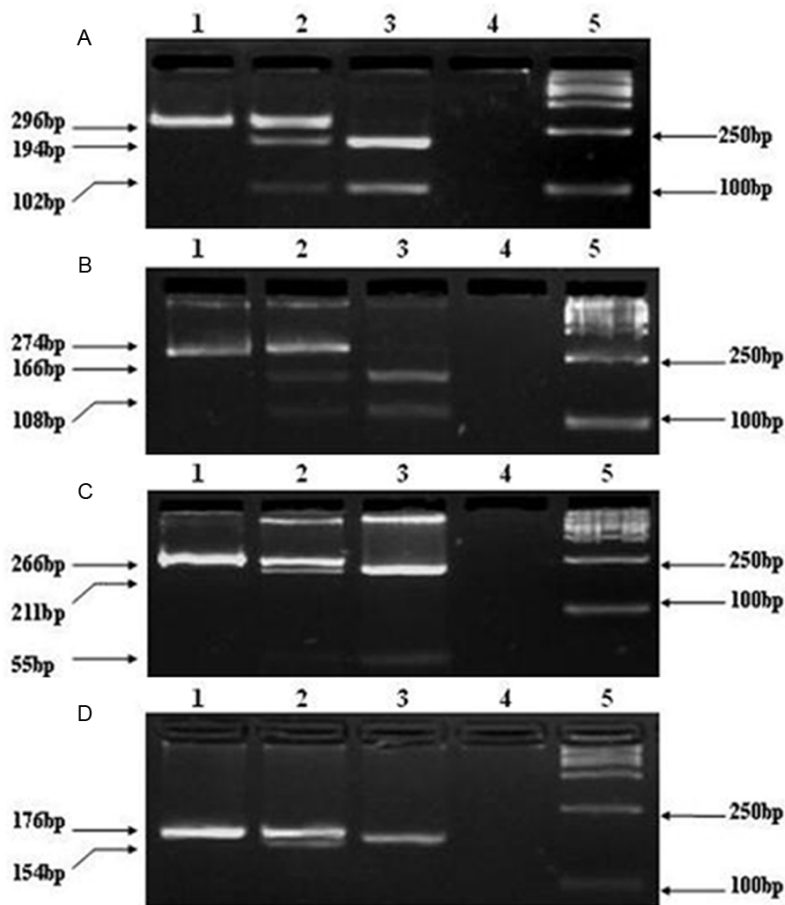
VEGF genotypes were performed using the PCR-based assays (Electrophoresis in 3% agarose gel). A: VEGF-2578 C>A genotype patterns: -2578 CC (296 bp) (lane 1), -2578 CA (296 bp + 194 bp + 102 bp) (lane 2) and -2578 AA (194 bp + 102 bp) (lane 3). Lane 4: water control; Lane 5: DNA marker. B: VEGF-634 G>C genotype patterns: -634 CC (274 bp) (lane 1), -634 GC (274 bp + 166 bp + 108 bp) (lane 2) and -634 GG (166 bp + 108 bp) (lane 3). Lane 4: water control; Lane 5: DNA marker. C: VEGF+936 C>T genotype patterns: +936 CC (266 bp) (lane 1), +936 CT (266 bp + 211 bp + 55 bp) (lane 2) and +936 TT (211 bp + 55 bp) (lane 3). Lane 4: water control; Lane 5: DNA marker. D: VEGF-1498 T>C genotype patterns: -1498 TT (176 bp) (lane 1), -1498 TC (176 bp + 154 bp + 22 bp) (lane 2) and -1498 CC (154 bp + 22 bp) (lane 3). Lane 4: water control; Lane 5: DNA marker.
